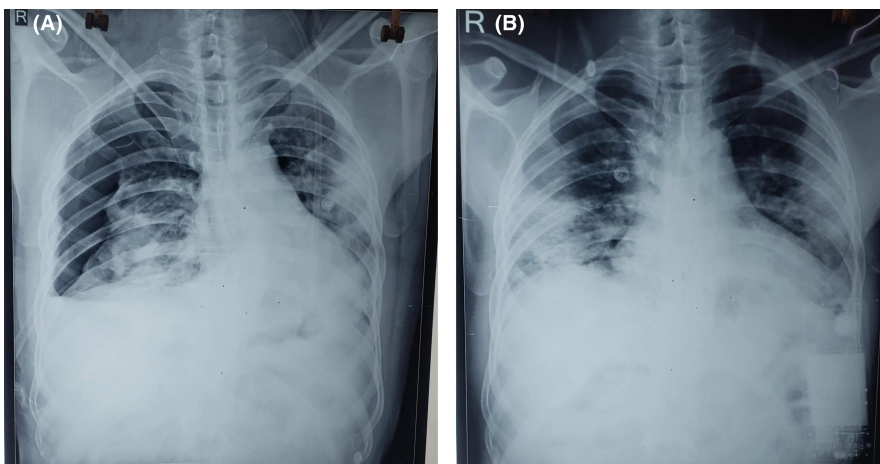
(A) Chest X-ray showed bilateral lung opacities with a visible visceral pleural line, absent lung markings, and peripheral radiolucency on the right side, suggesting pneumothorax. (B) Chest X-ray showing bilateral lung opacities (before pneumothorax).
